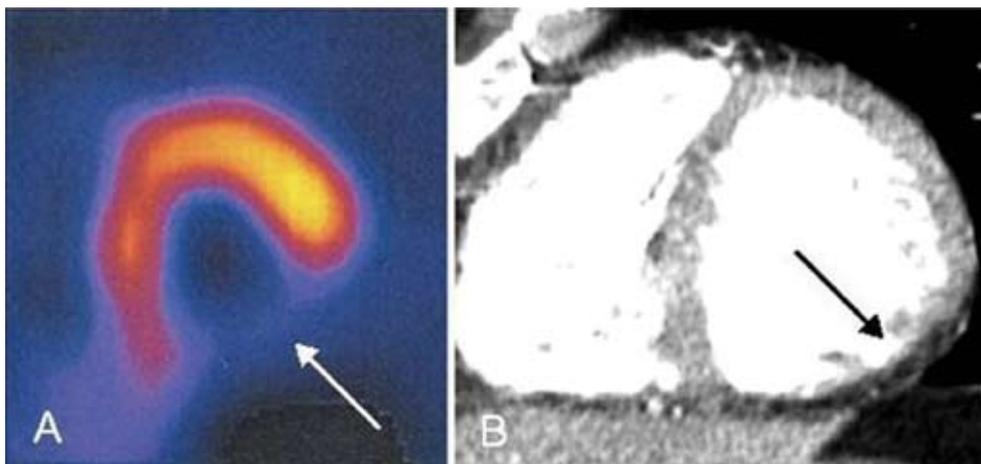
Example of a large perfusion defect on SPECT and MSCT of the patient depicted in Figure 3. (A) SPECT short-axis image showing a perfusion defect in the inferior wall (white arrow) at rest, (B) corresponding MSCT short-axis image in end-diastole, revealing a hypoenhanced area (black arrow) in the inferior wall, indicating a perfusion defect.
